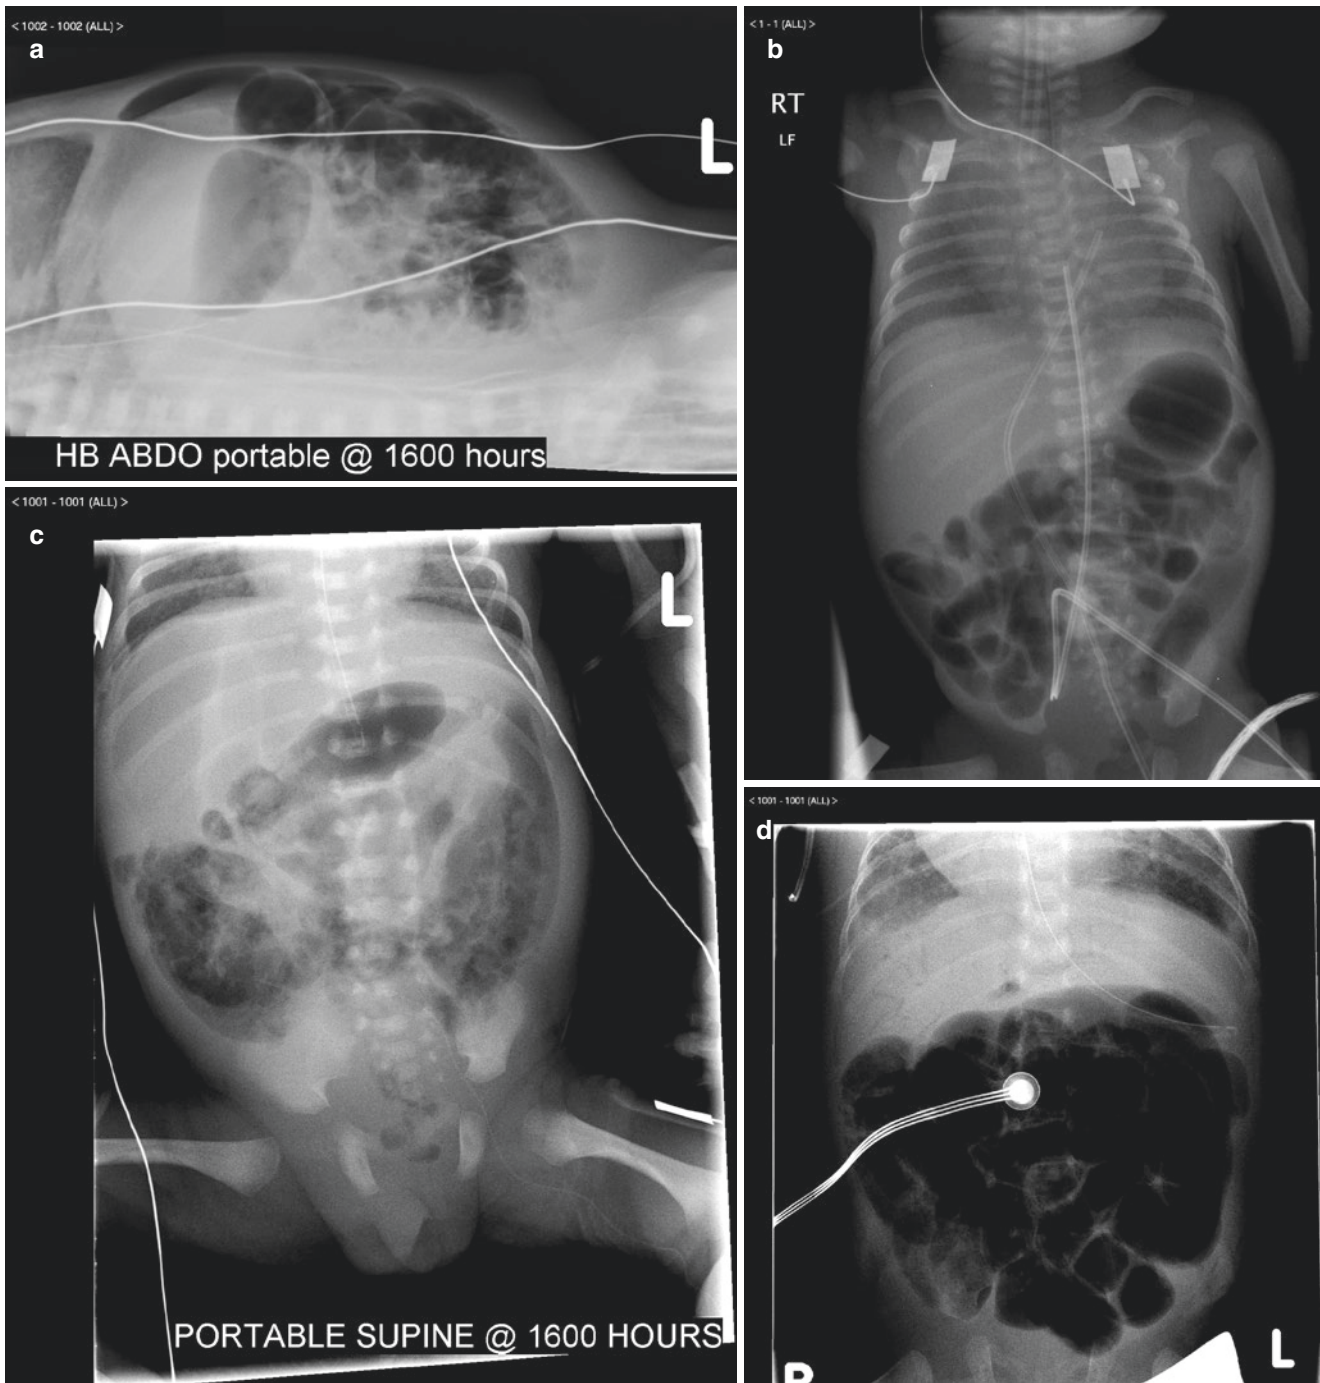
(a) Perforation of the bowel. A plain X-ray lateral shoot through showing the presence of free gas following perforation in necrotising enterocolitis. (b) Umbilical line catheter and femoral line catheter in a premature neonate with distended loops of bowel, early
